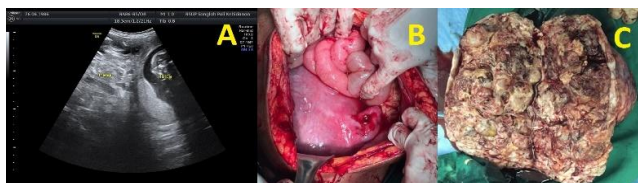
Ultrasonography and Macroscopy of Immature Teratoma Durante Operation. A. Left adnexal mass hypohyperechoic with size that cannot reach by the probe at 19 weeks 5 day GA; B. Uterus size corresponding with 18-20 weeks GA, left Fallopian tube normal, post-oophorectomy; C. Lobulated solid mass with multiseptate cystic inside it.
